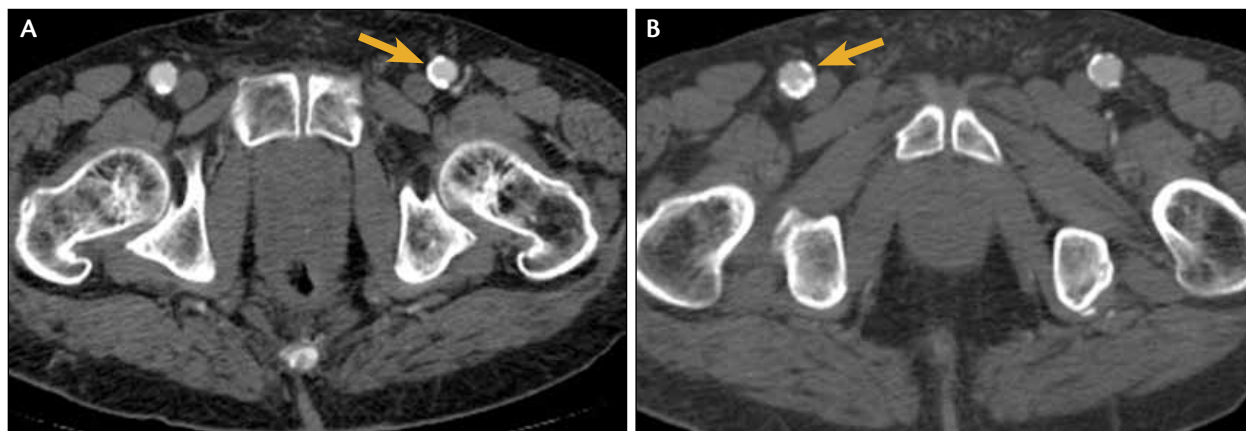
Preoperative CT imaging is useful to assess the location and degree of common femoral artery calcification.
